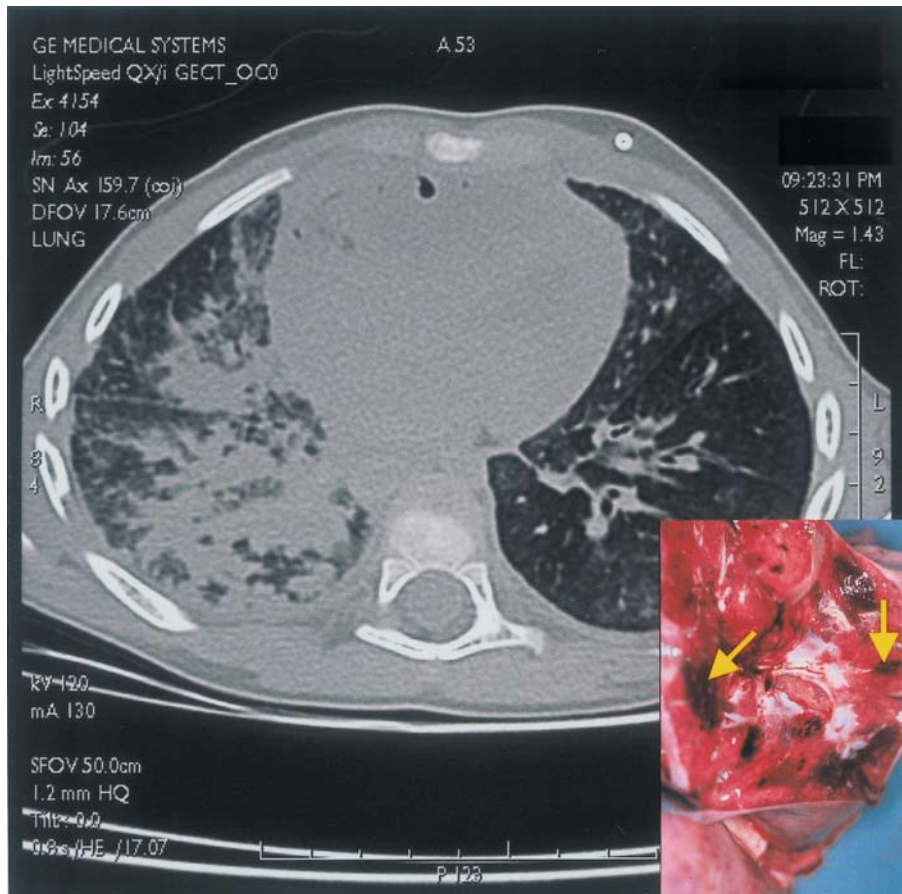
Aspiration of gastric acid (Case 009). Axial CT image showing partial lobular digestion of the lung parenchyma and atelectasis of the middle and inferior right lobes with isolated open bronchii. Inset: corresponding findings of lobular digestion at autopsy (arrows).
